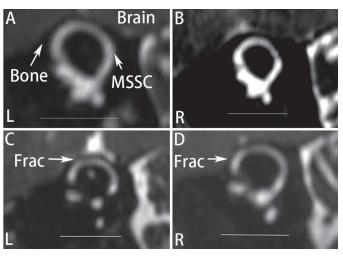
Magnetic resonance imaging scan comparison of superior semicircular canals (SSC) between the patient with SSC dehiscence (SSCD) syndrome and a patient without vertigo. Three-dimensional fast imaging employing a steady-state acquisition (FIESTA) sequence was used to acquire the images with a 3.0 T machine (GE Signa HDxt 3.0T MRI system, 8-channel HD head coil). (A, B) A continuous dark border was clearly observed between the grey signal of the brain and the bright membranous SSC (MSSC) in a patient without vertigo, and (C, D) The distance between the grey brain and bright MSSC in the patient with SSCD syndrome was narrow even disappeared.
